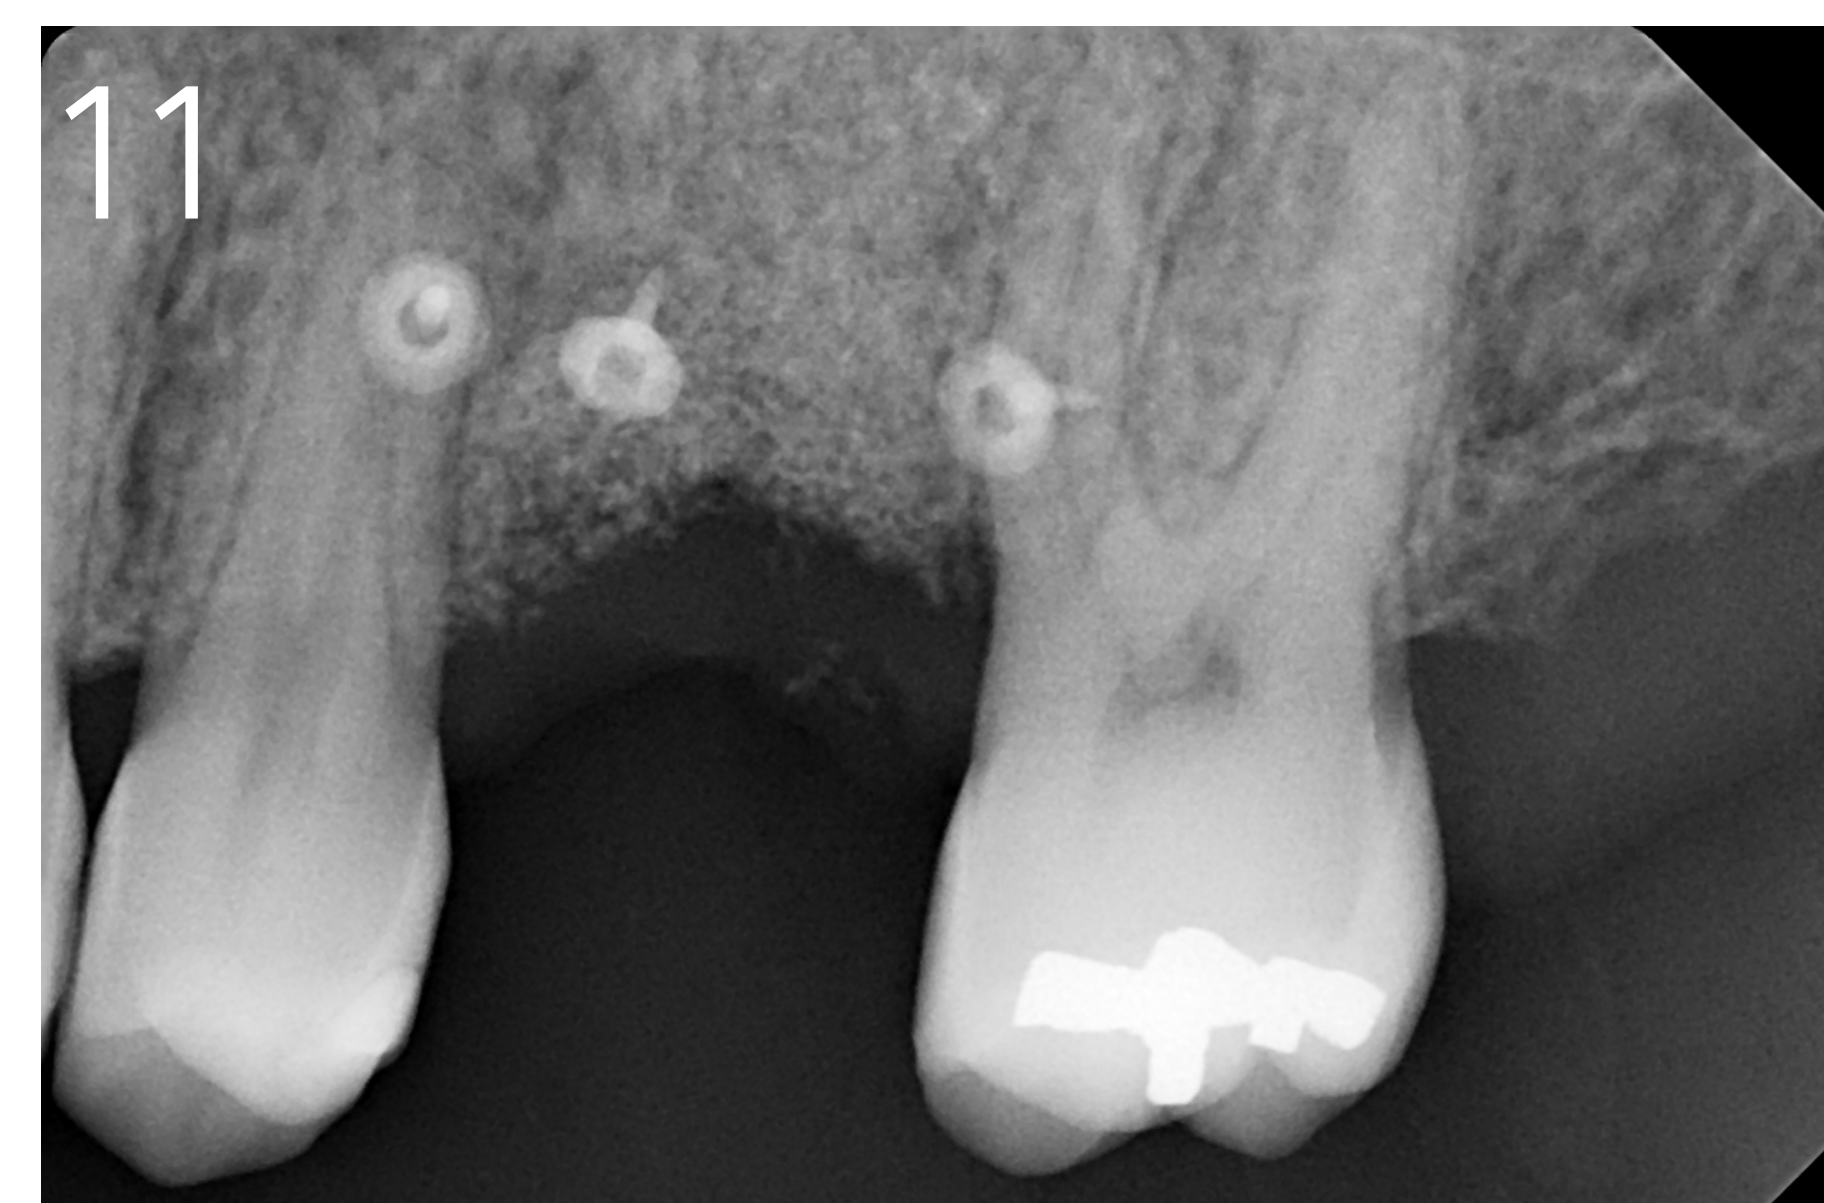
4 month follow-up X-ray
